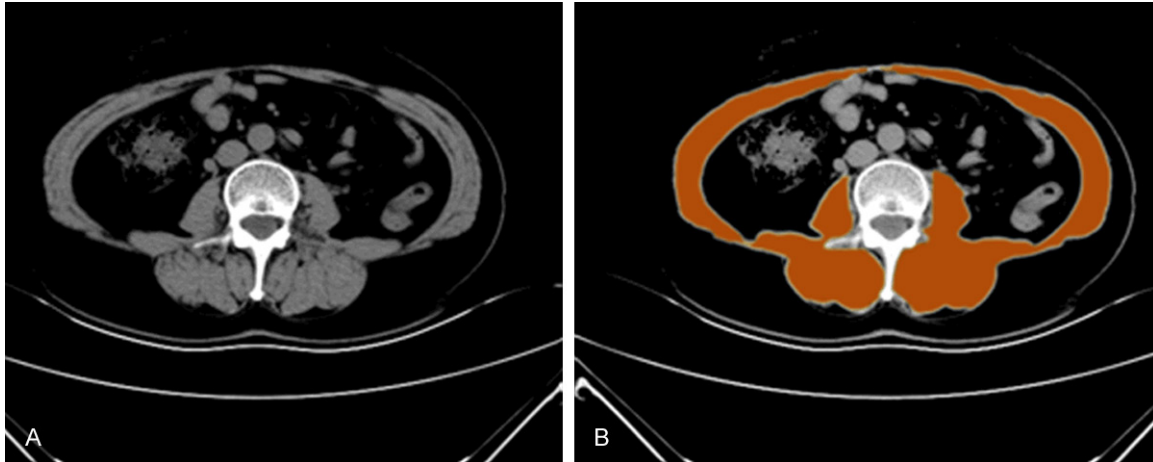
The measurement of the area of skeletal muscle. CT scan showing the area of skeletal muscle mass at the third lumbar vertebra (A), The area of skeletal muscle was highlighted orange (B).
